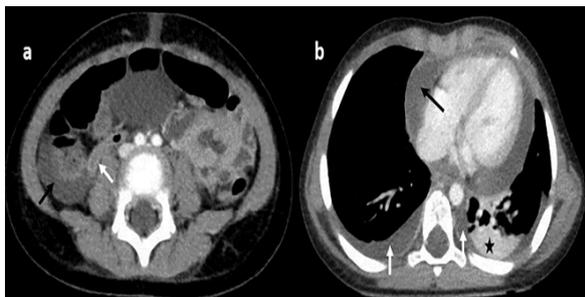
Multisystem inflammatory syndrome in children (MIS-C) in a 2-year-old girl presented with fever, abdominal pain, and shortness of breath 3 weeks after infection with SARS-CoV-2 virus. Axial CT image (a) reveals mild free fluid in the right lower quadrant (RLQ) and appendix wall hyperenhancement with normal luminal diameter containing air bubbles (black and white arrows, respectively). In lower thoracic levels (b), pericardial effusion (black arrow), bilateral pleural effusion (white arrows), and consolidation in the lower lobe of the left lung (black star) are depicted.
